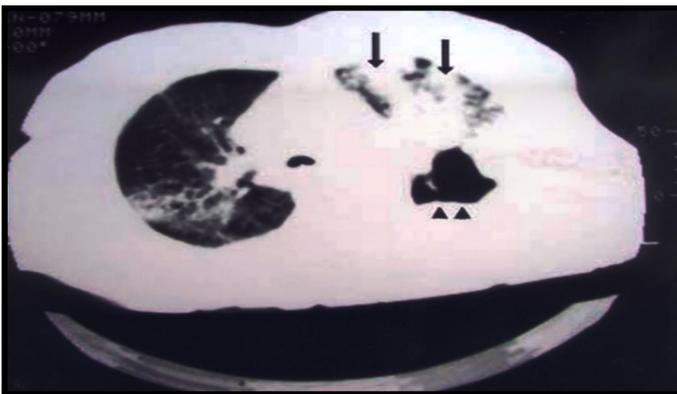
Computed tomography chest consolidation in the left upper lobe marked by arrows and a large cavity marked by arrow heads. Note also increased interstitial shadowing on the right (see text).
